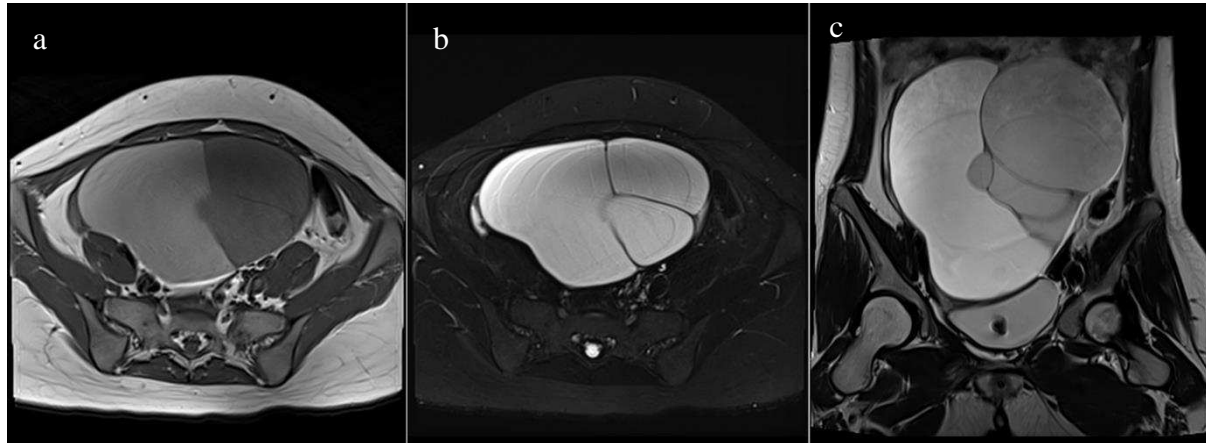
A 19-year-old female with primary amenorrhea and abdominal pain. Pelvic MRI shows the left endometrioma and hemosalpinx (a), which appears hyperintense at the T1WI; (b) hyperintense at T2WI Fat Sat, T2 Shading (+); (c) coronal T2WI (Courtesy of Dr. Soetomo Hospital)
